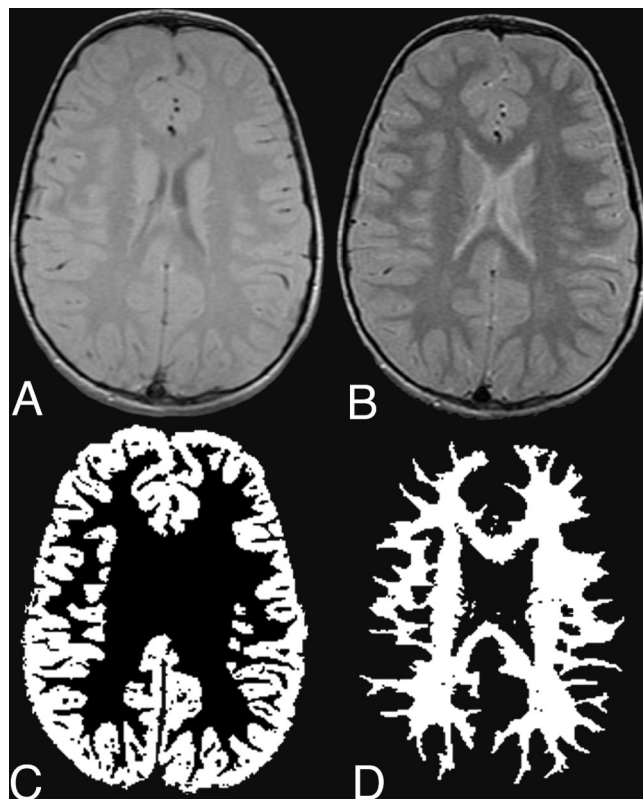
(A) Proton density image; (B) T2-weighted image; (C) segmentation of cortical gray matter; (D) segmentation of white matter.
